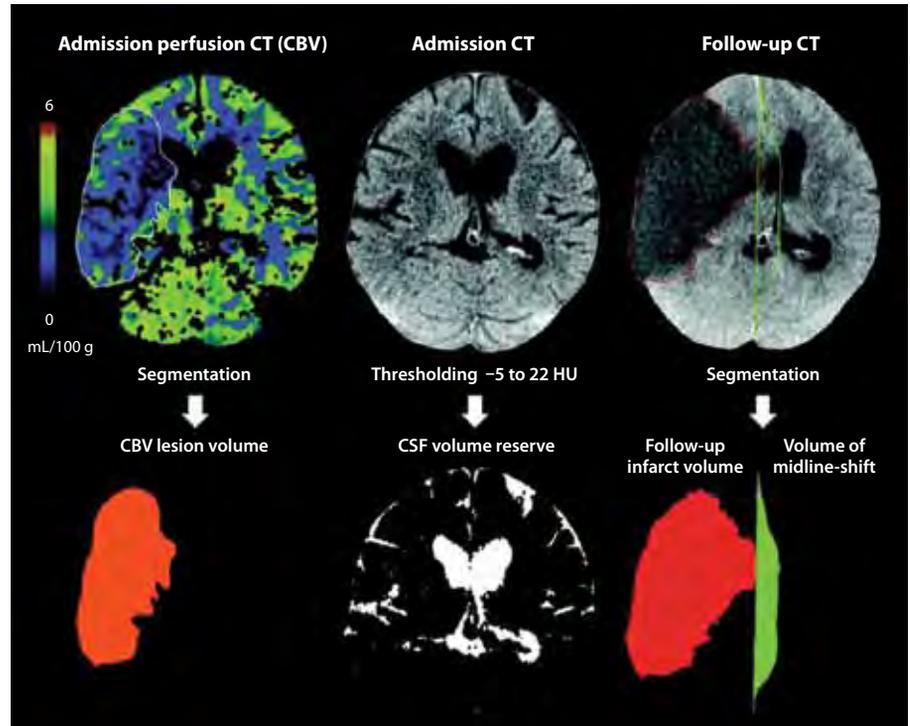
Transverse computed tomography (CT) images showing changes in cerebral blood volume (CBV) and infarct size on admission and at follow-up in a patient with acute ischemic stroke; CSF = cerebrospinal fluid. Figure courtesy of Osama Zaidat, MD.
